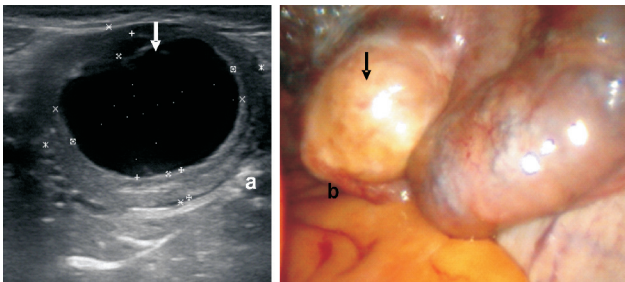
Luteal cyst (arrow). (a) Ultrasound image (b) Laparoscopic image.
